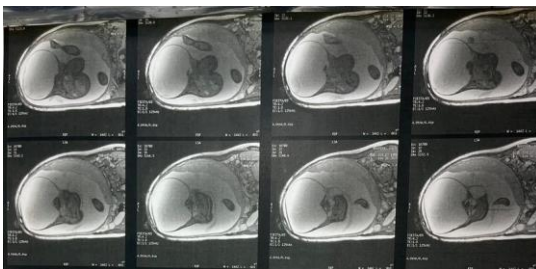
Fetal MRI at 31 weeks of gestation showing a predominantly exophytic sacrococcygeal teratoma consistent with Altman type I, associated with polyhydramnios.
